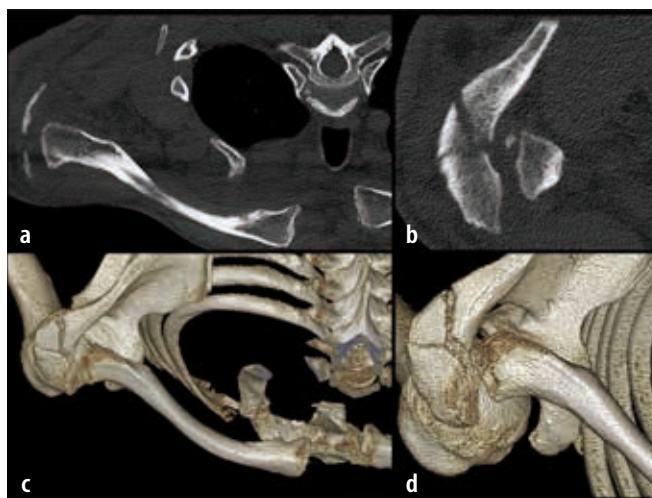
CT scan from the case shown in Fig. 17-1: a) SC dislocation visible in CT horizontal section; b) fracture of the acromial angle and posterior AC dislocation (type IV) visible in CT horizontal section; c) 3D CT reconstruction of a fracture of the acromial angle, posterior AC dislocation and anterior SC dislocation; d) 3D CT reconstruction of a fracture of the acromial angle and posterior AC dislocation.
